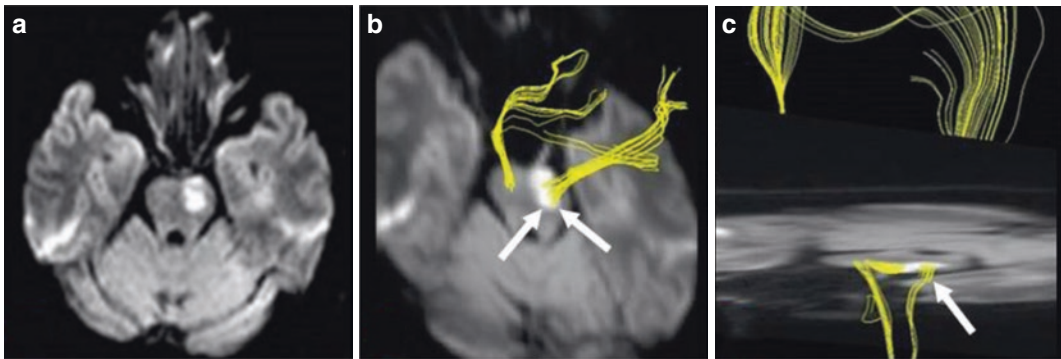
Left pontine infarction. A 62-year-old female patient who presented with right limb weakness and slurred speech for 2 d. Motor dysfunction remained after 3 months of routine medical treatment and rehabilitation training. Transverse DWI shows left pontine infarction
